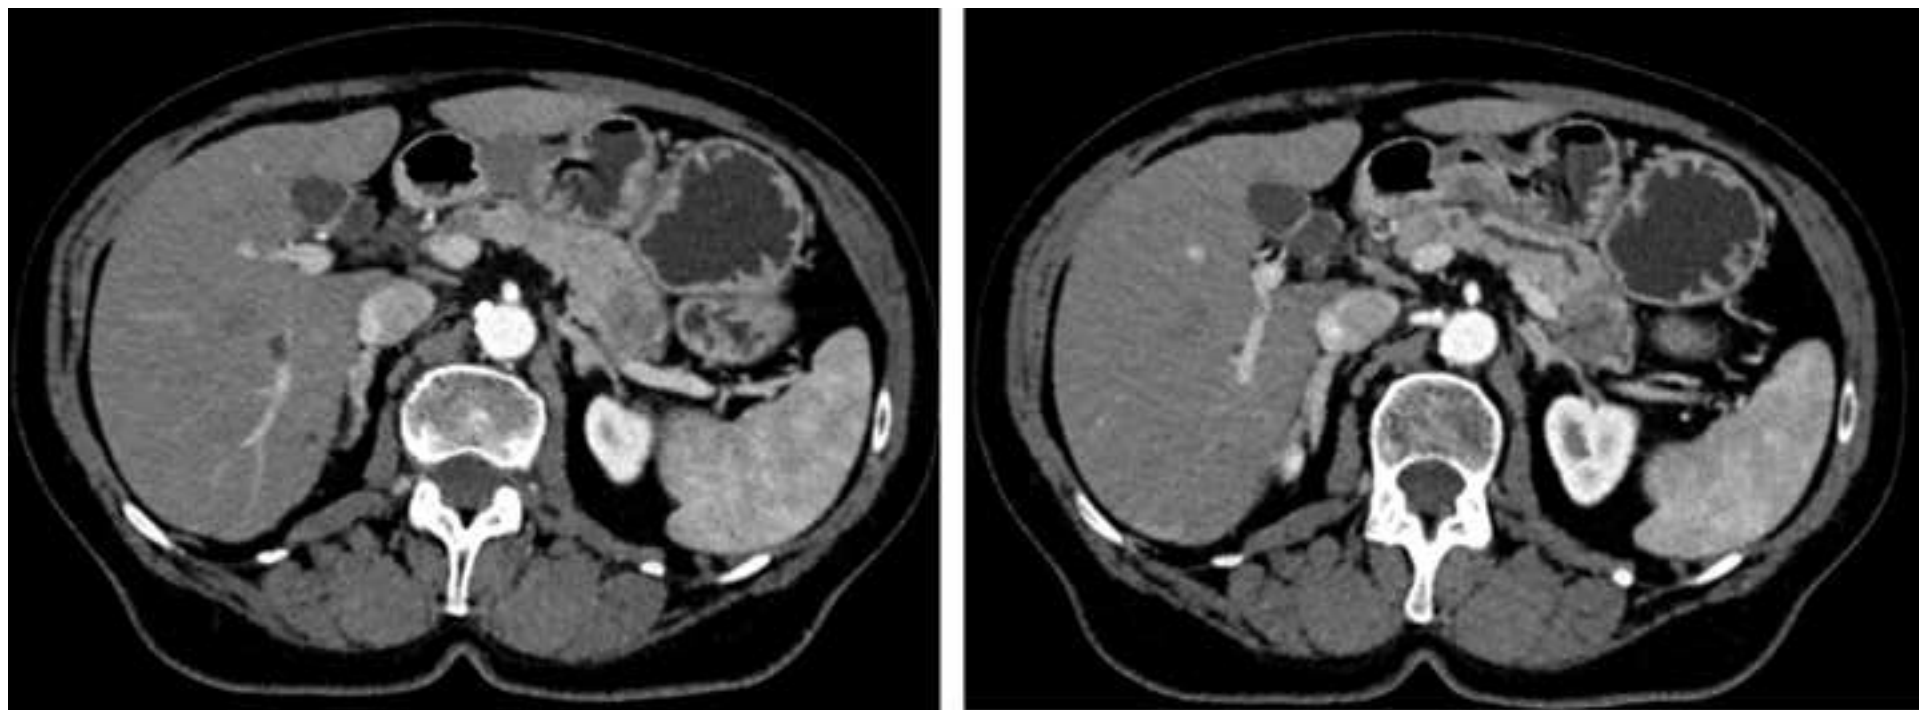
Preoperative CT-scan
